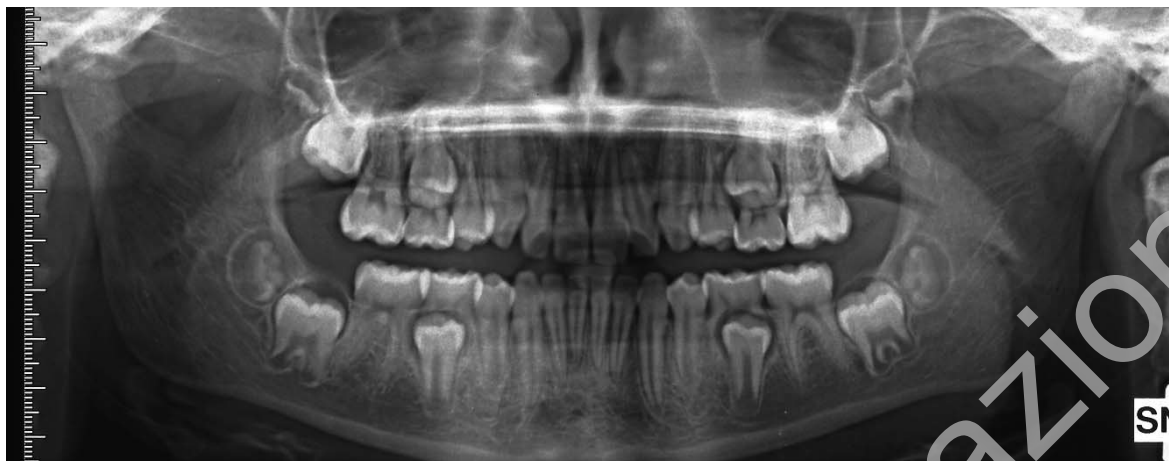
Orthopantomography before treatment (T0).
